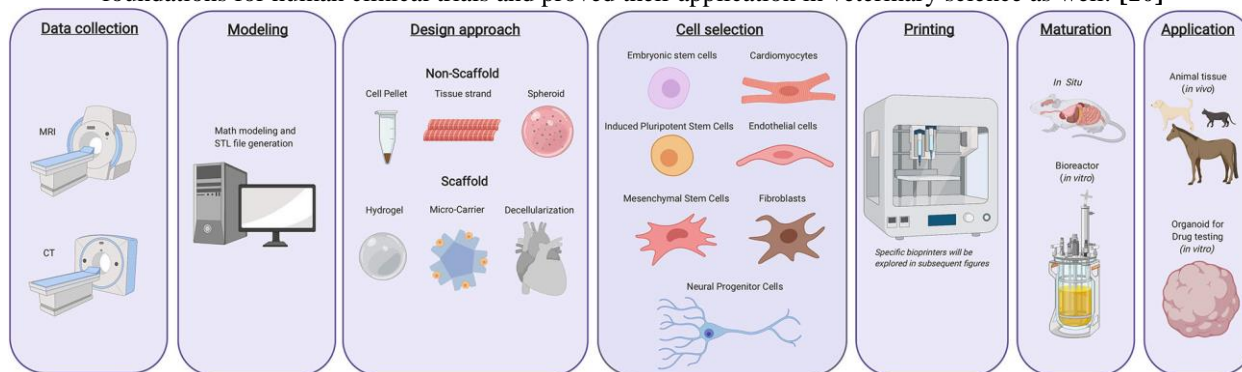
The patient's data is collected through an MRI or CT scan, and with the help of AM and CAD, a model is designed. In the design approach, biomimicry and self-assembly are used. According to the model, cells will be selected and then printed. Once the printing is done, that structure must be incubated and developed, and then there will be in vivo transplantation. [9]
